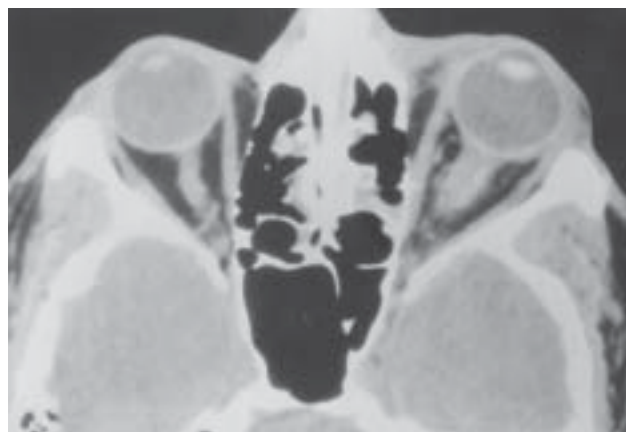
A computed tomography (CT) scan demonstrating a left optic nerve sheath hematoma. Preseptal swelling is also present. CT scan: Courtesy of Department of Ophthalmology, Allegheny General Hospital, Pittsburgh, Pa.
